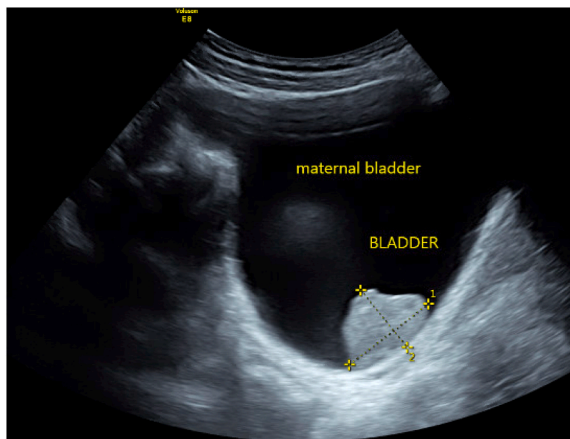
Maternal bladder polyp on 12-week ultrasound (3.34 × 2.46 cm).
